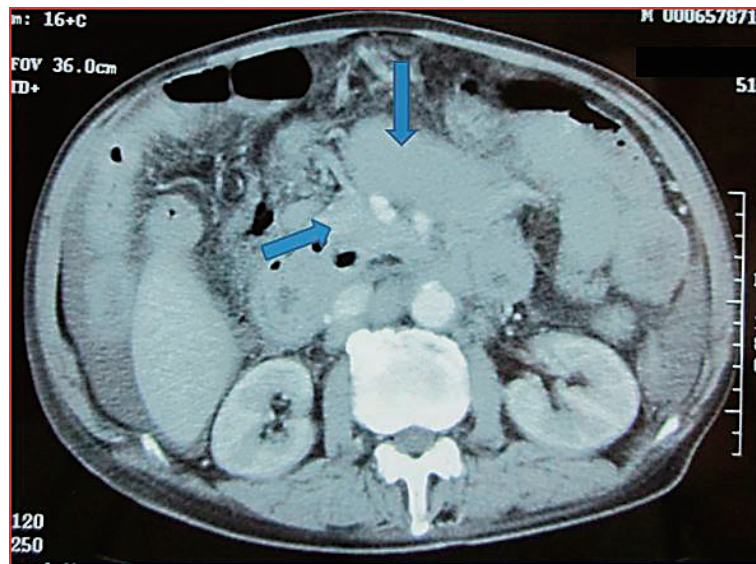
Contrast computed tomography scanning of the abdomen, which was performed on admission, shows extensive wall thickening of the colon and small intestine (arrows), and mesenteric lymphadenopathy.
